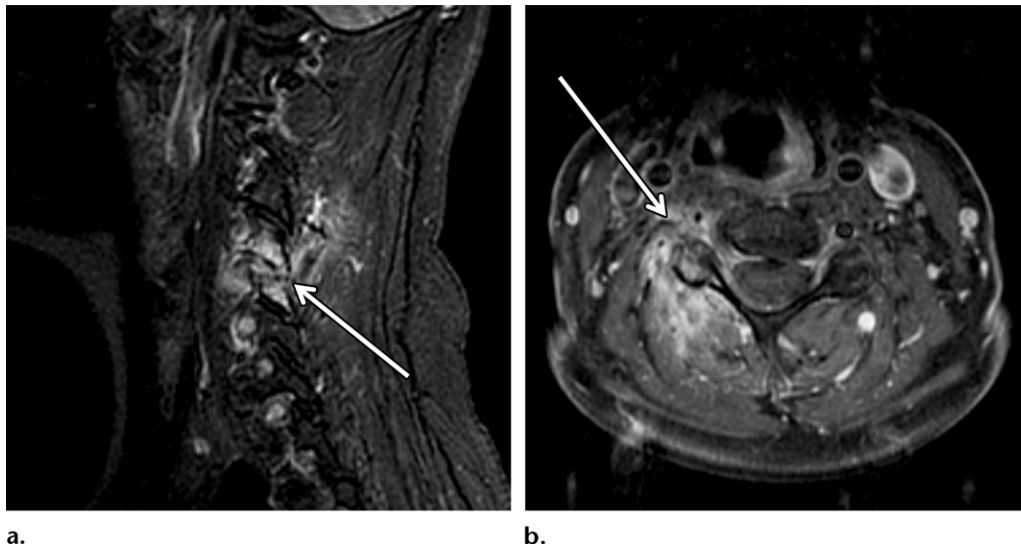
Septic facet arthritis in a 58-year-old woman with fever, neck pain, and stiffness. Sagittal fat-suppressed T2-weighted (a) and contrast-enhanced T1-weighted (b) MR images show edema at one of the cervical facet joints, with adjacent soft-tissue inflammation (arrow) that extends into the prevertebral and paraspinal spaces and the adjacent neural foramen.
